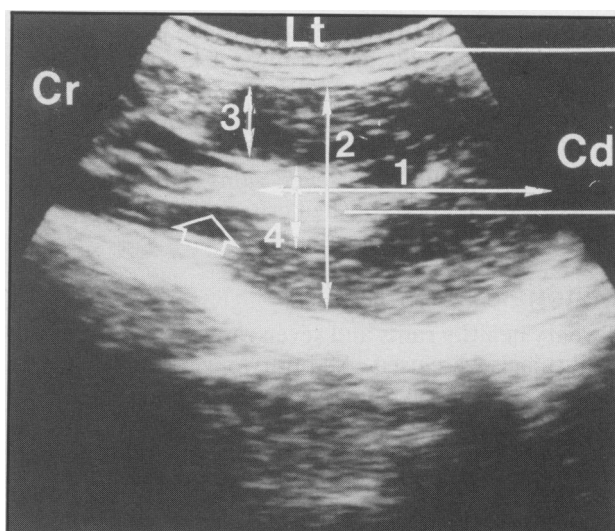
Ultrasonogram of a transverse section through the right kidney in the region of the renal hilus (arrow). Top line = abdominal wall; second line = renal sinus; Cr = cranial; Cd = caudal; Lt = lateral; 1 = width of the kidney; 2 = depth of the kidney; 3 = diameter of renal parenchyma; 4 = diameter of renal sinus.
